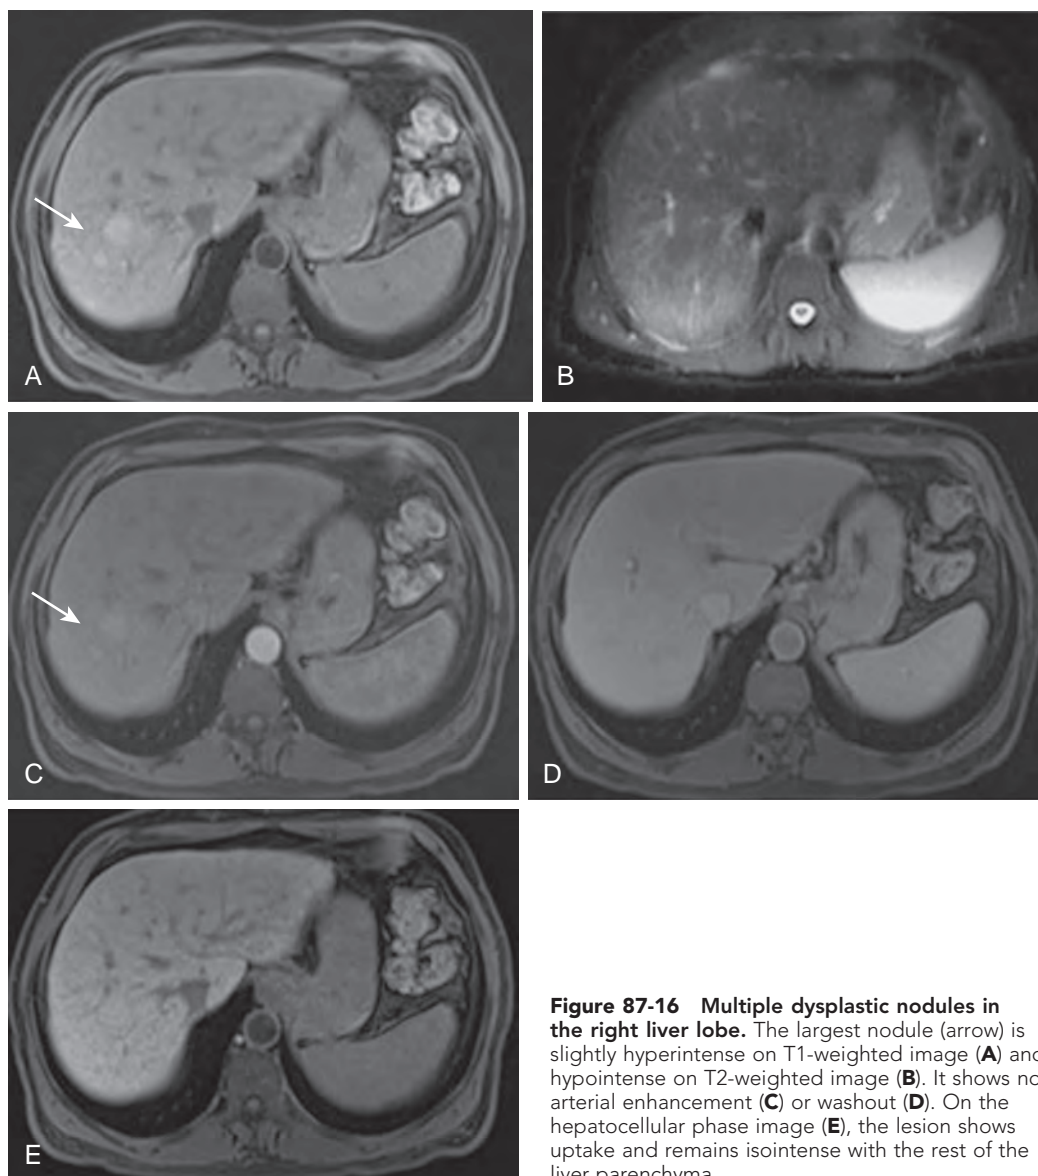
Multiple dysplastic nodules in the right liver lobe. The largest nodule (arrow) is slightly hyperintense on T1-weighted image (A) and hypointense on T2-weighted image (B). It shows no arterial enhancement (C) or washout (D). On the hepatocellular phase image (E), the lesion shows uptake and remains iso-intense with the rest of the liver parenchyma.
